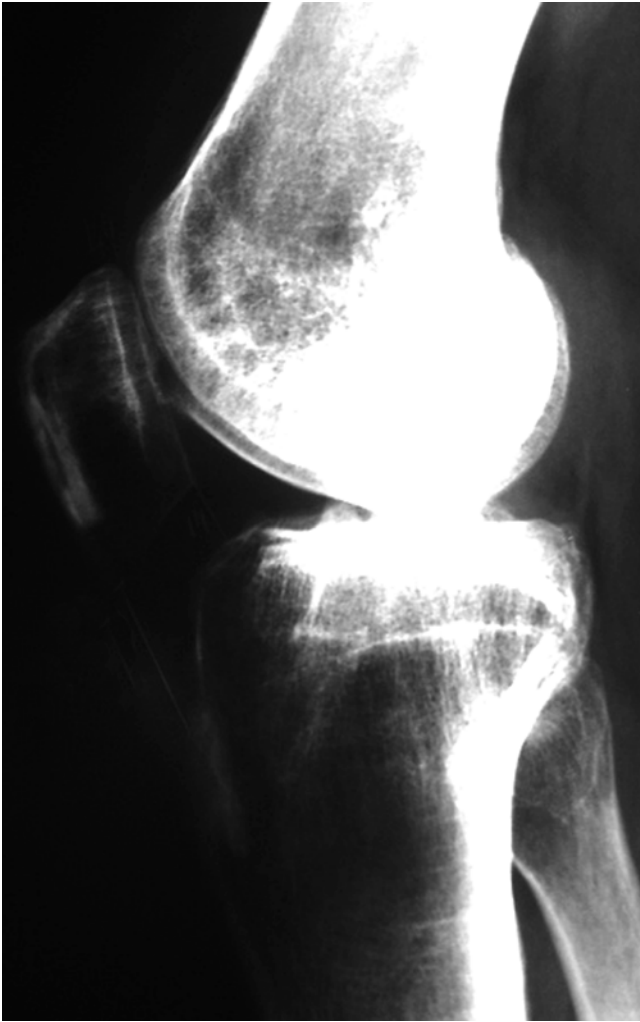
Lateral radiograph of the knee showing patella infera
